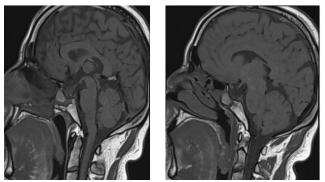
Follow-up pituitary MRI in sagittal T1-weighted imaging revealing an empty Sella turcica
